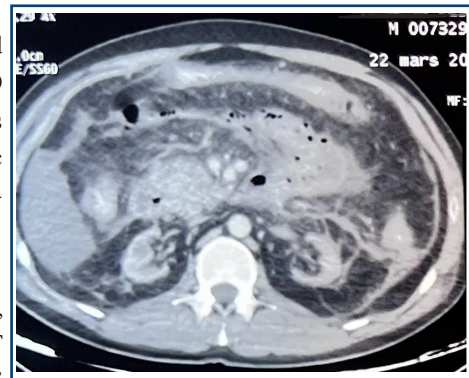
Abdominal CT scan showing necrotic flow (clinical case 1)
